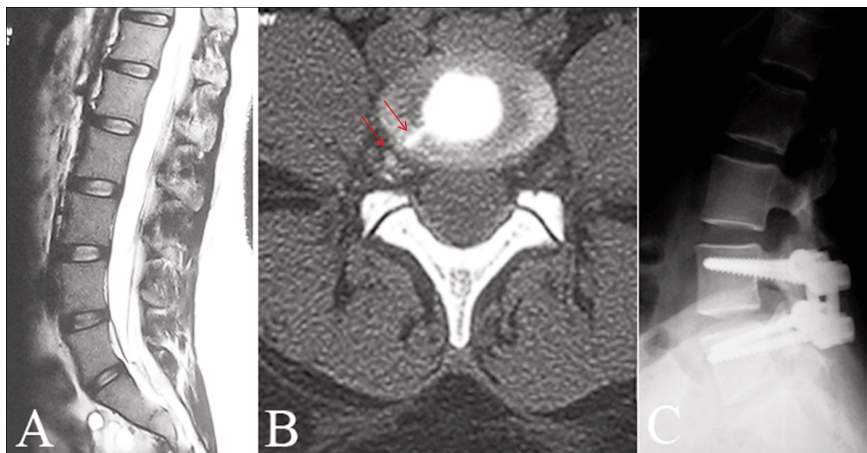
A) Normal sagittal T2-weighted magnetic resonance imaging; B) computed tomography discography showing contrast medium in the spinal canal and vertebral foramen (note the lateral location of the annulus fibrosus tear); C) a postoperative lateral lumbar radiograph of the patient.
